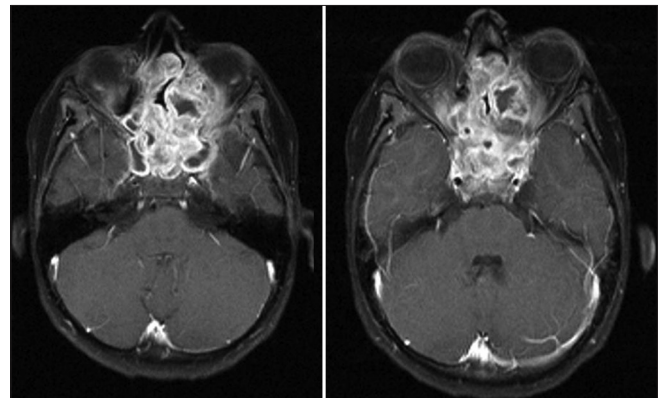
Magnetic resonance imaging with contrast showing intracranial extension
